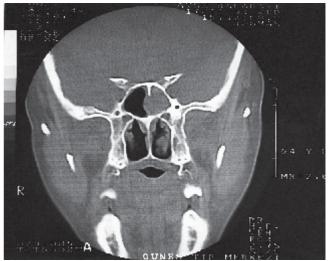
Coronal CT scan of the patient from Figure 6 showing opacity in the left sphenoid sinus.
